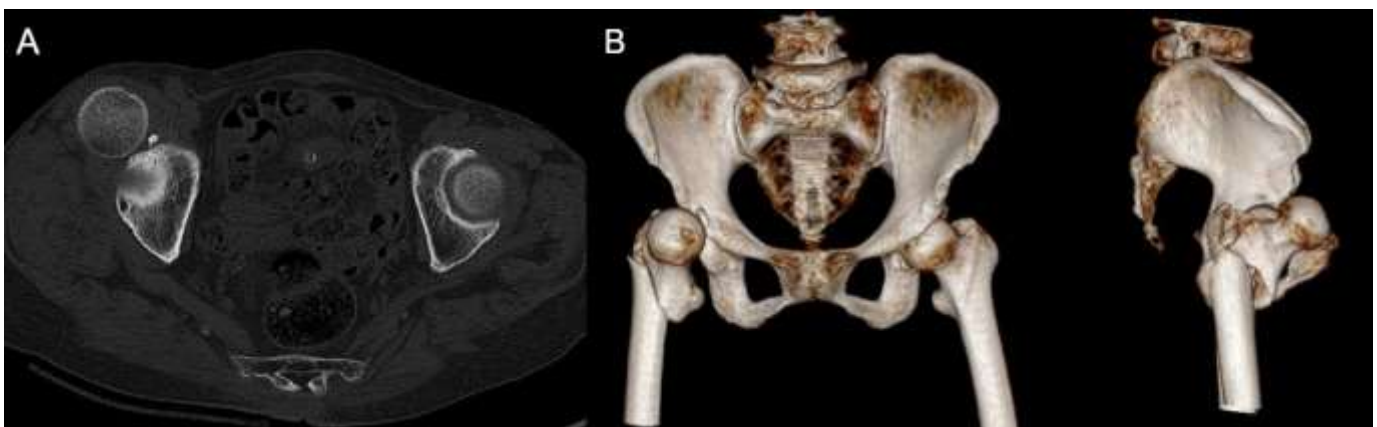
(A) Axial section of the computed tomography scan shows acetabular anterior wall fracture combined with anterior dislocation of the hip joint. (B) Three-dimensional reconstruction computed tomography images show anterior dislocation.
